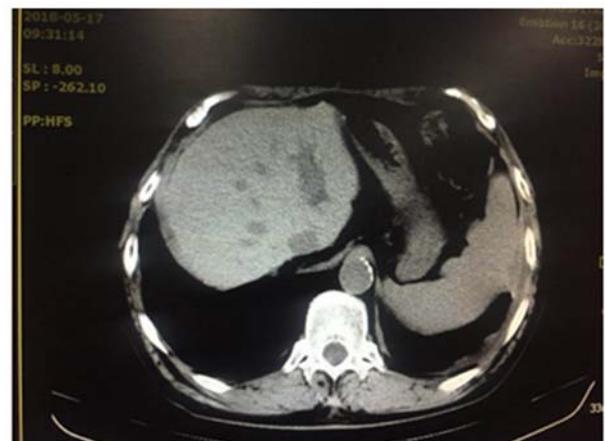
Abdominal CT after liver transplantation. All results of the abdominal CT were normal.
